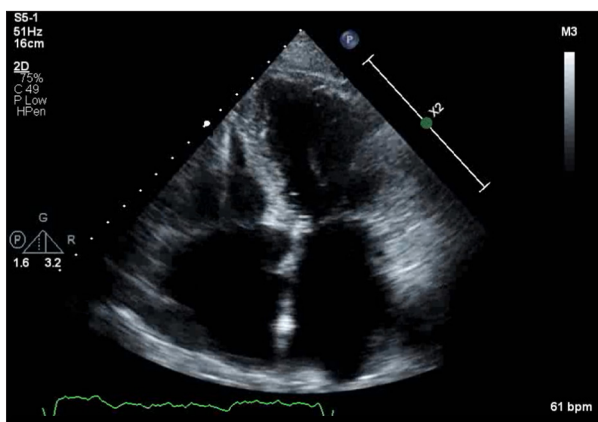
Resolution of the cardiac mass after chemotherapy. Apical 4-chamber view from a repeat transthoracic echocardiogram completed 6 weeks after chemotherapy demonstrated resolution of the cardiac mass after lymphoma treatment.
